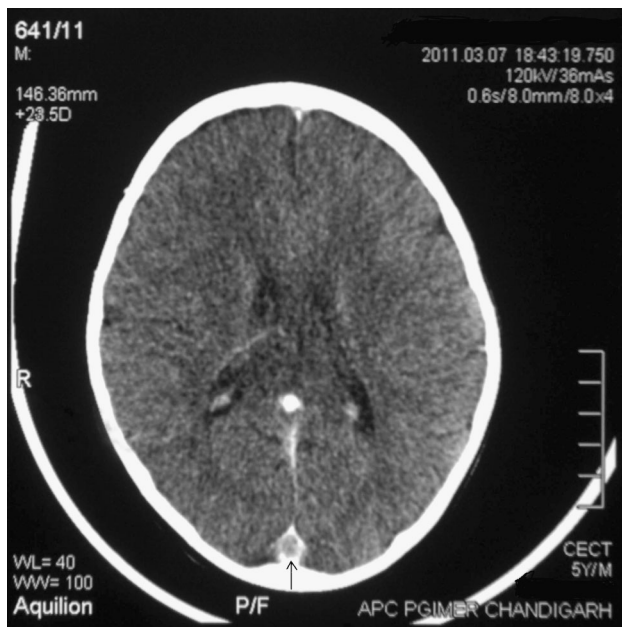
Axial contrast-enhanced cranial CT shows a filling defect in the region of the venous confluence (*empty delta sign*)
